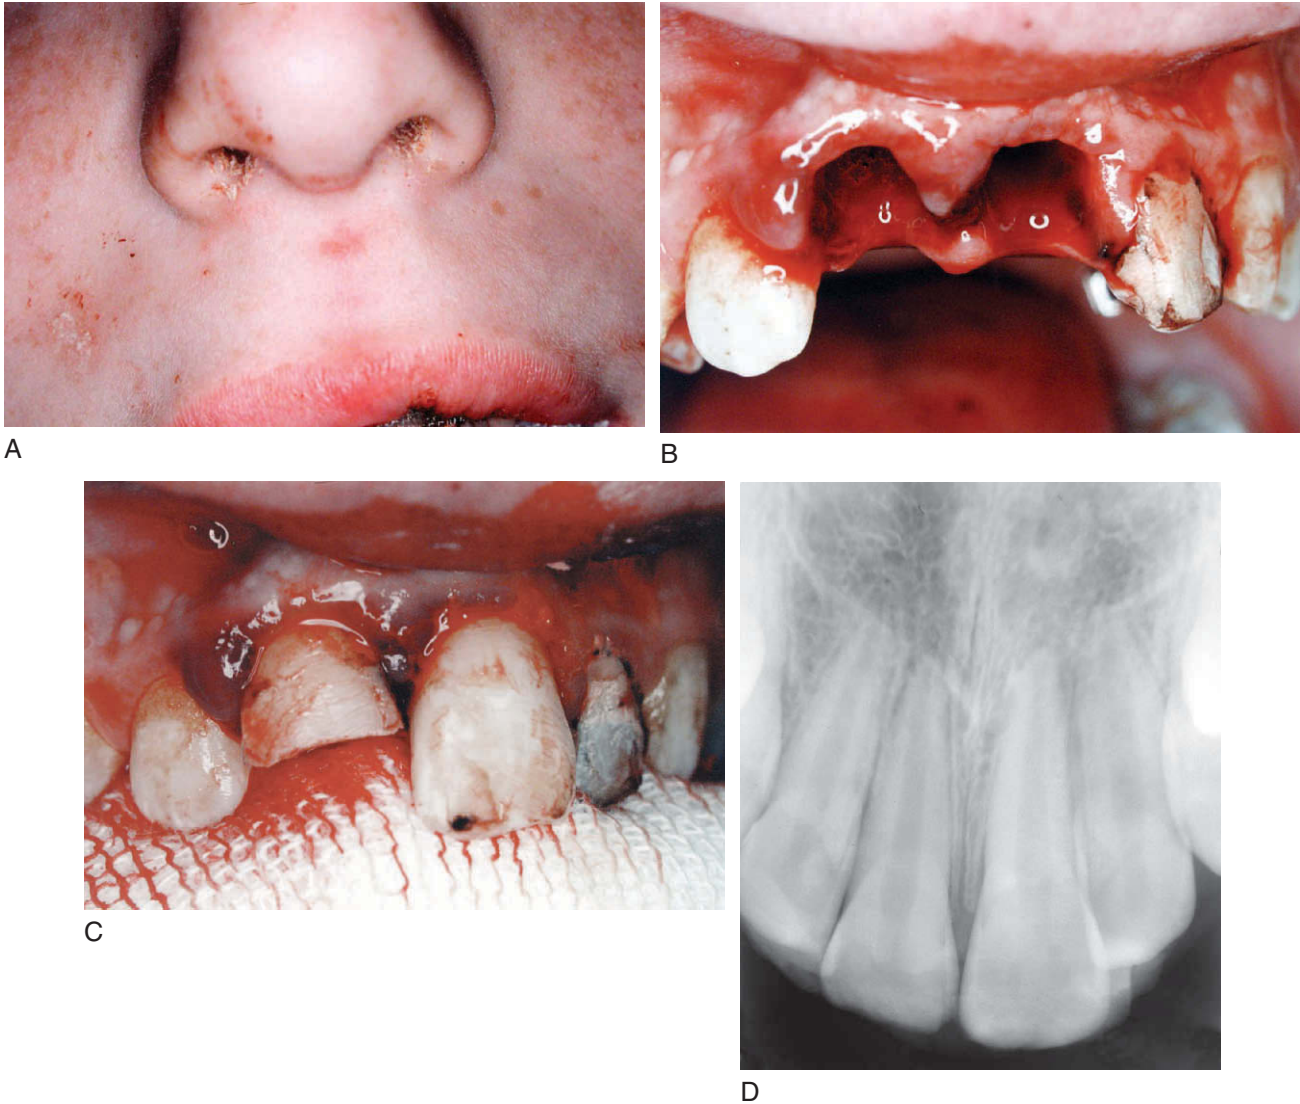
Eleven-year-old male fell while running, causing avulsion of both maxillary central incisors. He presented to the dental office 1 hour after trauma with the teeth soaking in a water container. A, Note the facial lacerations. B, Copious alveolar and gingival bleeding. C, Both incisors were immediately replanted; patient is biting on gauze while the splint is being fabricated. D, Post-treatment radiograph after replantation.
